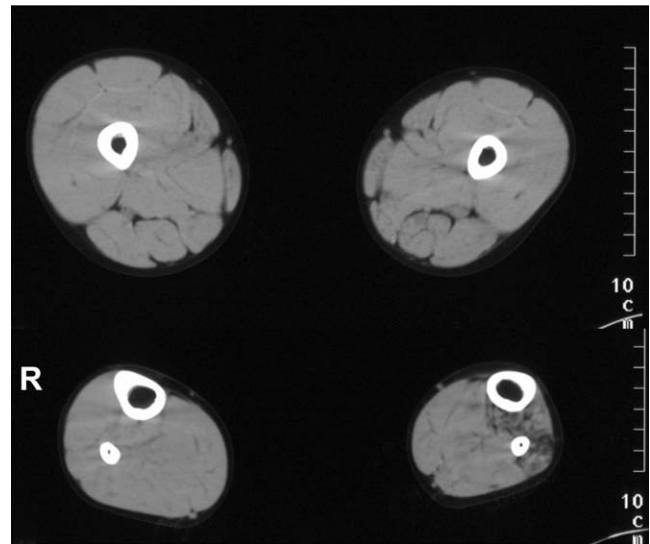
Muscle CT. The volumes of the left thigh (upper) and calf muscle (lower) are less than those of the corresponding muscles on the right.
